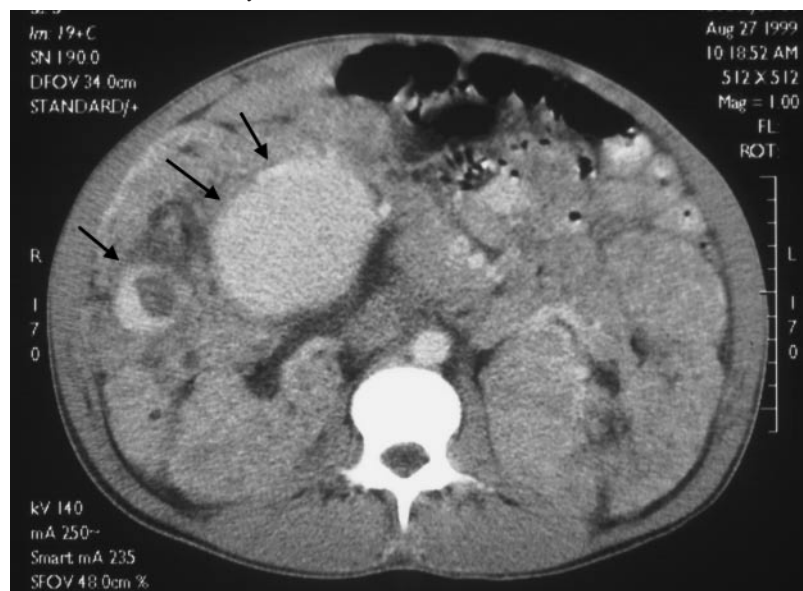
MRI scan of the abdomen shows large kidneys with multiple angiomyolipomas and two intrarenal aneurysms (black arrows).
